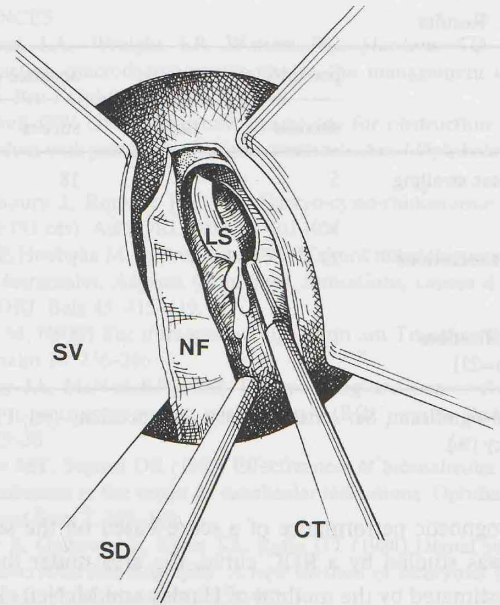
Left nasal fossa. LD and LS are opened (SV: nasal speculum valves; SD: suction device; CT: coagulating tip; NF: nasal flap; LS: lachrymal sac).
